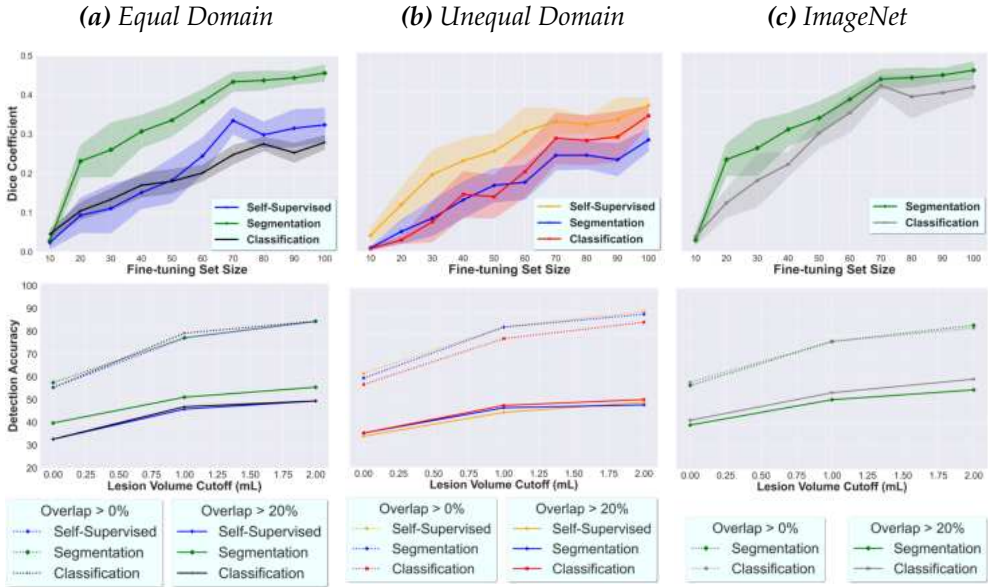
Spatial agreement (top) and lesion detection accuracy (bottom) for the stroke lesion segmentation task. The spatial agreement is assessed using the Dice coefficient as a function of the fine-tuning set size. The lesion detection accuracy is given as a function of the lesion volume cutoff, which is the minimal volume for which lesions are considered detected. The lesion detection accuracy is calculated with 0% and 20% overlap cutoffs (bottom). (a) Equal domain (T1-MRI) pre-training. Included source tasks are self-supervised, segmentation, and classification. (b) Unequal domain (natural images) pre-training. Included source tasks are self-supervised, classification, and segmentation. (c) Comparison of full-extent ImageNet classification pre-training and pre-training on equal domain and task: brain tissue segmentation.
